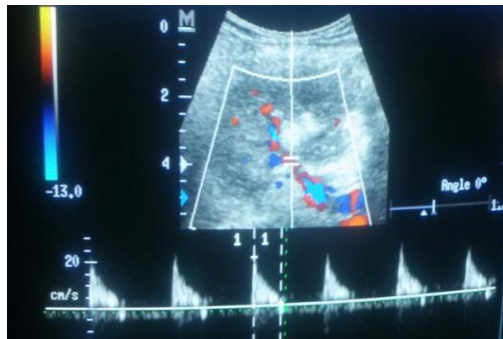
Doppler image reveals elevated resistive index of the renal artery (RI=0.95) with reduced cortical perfusion. The case was interpreted as features of rejection.
